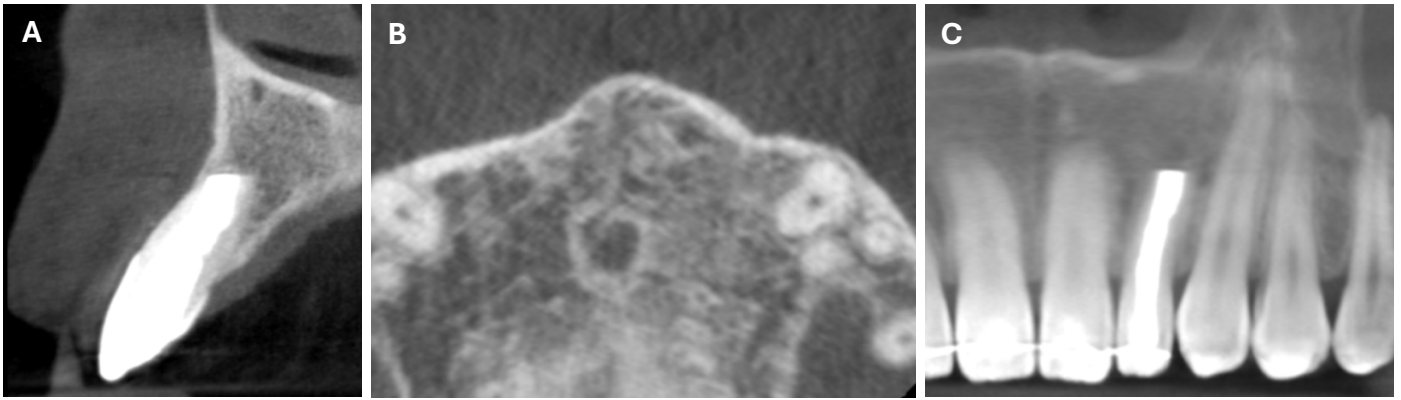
A 2-year follow-up CBCT of the tooth 22. (A) sagittal plane; (B) axial plane; (C) panoramic view from CBCT. CBCT as of 2022.
